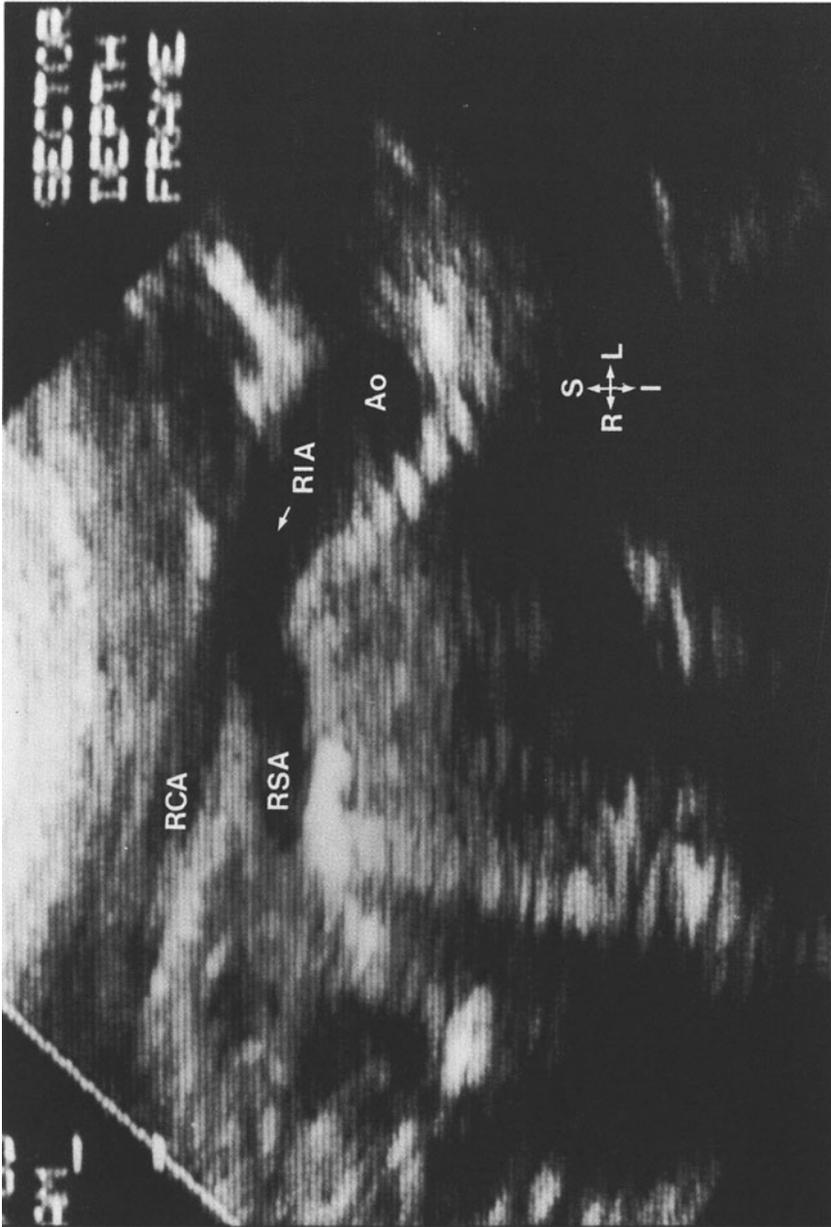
Two-dimensional echocardiography of the normal right innominate artery obtained by scanning from the suprasternal notch toward the right shoulder. *Ao*, aorta; *I*, inferior; *L*, left; *R*, right; *RCA*, right carotid artery; *RIA*, right innominate artery; *RSA*, right subclavian artery; and *S*, superior.
